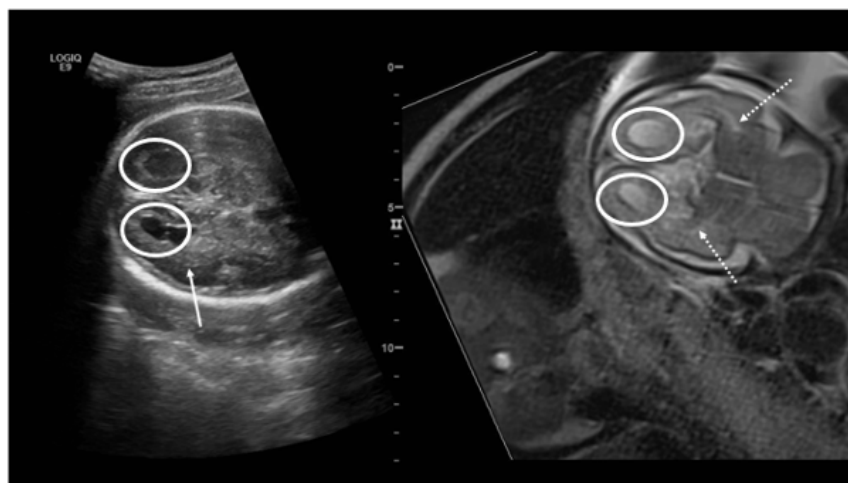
Fusion image of sonographic and MR image in the axial plane of a fetus at a gestational age of 22 weeks with proven CMV infection. Bilateral occipital cysts are seen (white circles). On the sonographic image, there is a discrete hyperechoic zoom around the ventricular wall (white arrow). On MR, increased signal intensity is noted at the periventricular crossroads (dashed white arrow).
